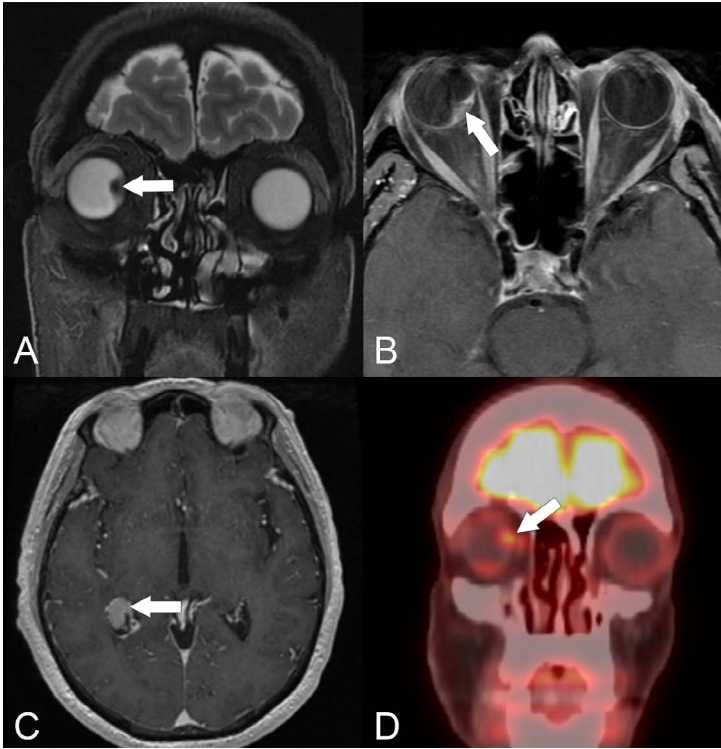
A 67-year-old male with a pituitary metastasis from papillary thyroid carcinoma-follicular variant (PTC-FV). (A) Coronal T2 MRI shows a hypointense mass involving the choroid of the right eye (arrow). (B) Axial T1 post-contrast MRI shows the enhancing right choroidal metastasis (arrow). (C) Axial T1 post-contrast MRI shows a metastasis involving the choroid plexus in the atrium of the right lateral ventricle (arrow). (D) Coronal PET/CT shows an FDG-avid right choroidal metastasis (arrow).
